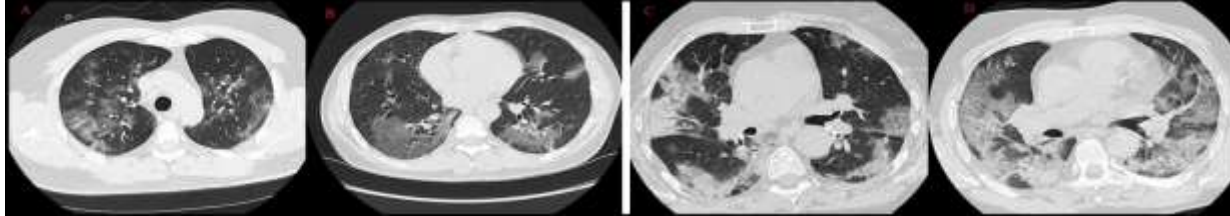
Positivity of patients on CT scan
